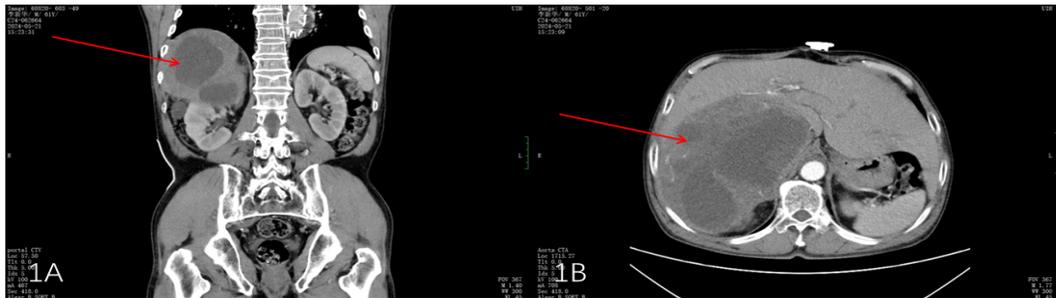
Preoperative contrast-enhanced CT revealed a right adrenal tumour and a thoracic aortic stent graft.
